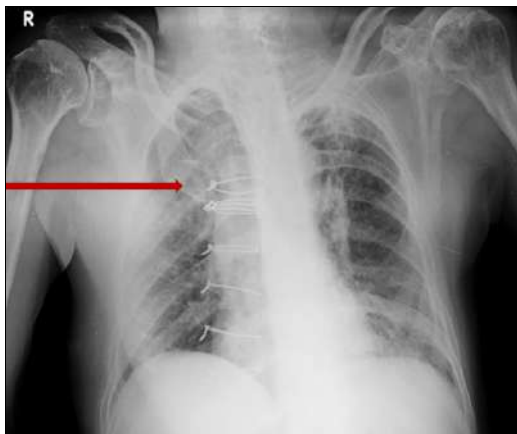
X-Ray Chest shows bony expansion with mixed lytic sclerotic changes noted in anterior aspect of Rt 1-4th ribs
